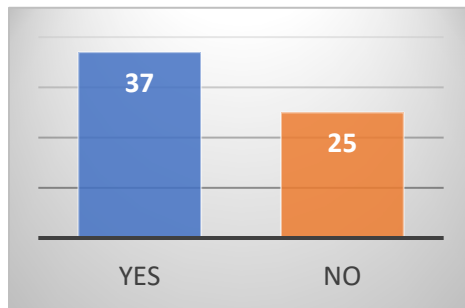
Are your plea bargain decisions in DWI cases somewhat influenced by screening or assessment results?
